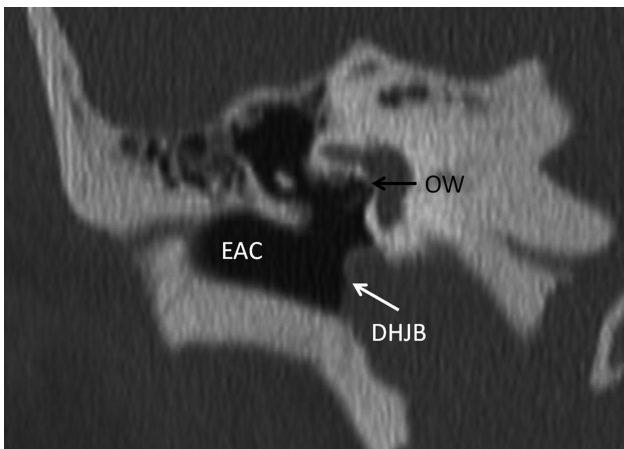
Preoperative high-resolution computed tomography image of the temporal bone, coronal section. DHJB = dehiscence high jugular bulb; EAC = external auditory canal; OW = oval window.
